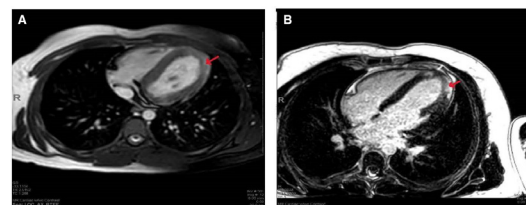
Case 1: Cardiac MRI (A) long axis view showing an abnormal high signal intensity of myocardium highlighted by the arrows. (B) four-chamber views post gadolinium showing late gadolinium enhancement.
